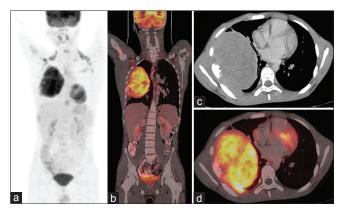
(a) Maximum intensity projection image showing fluorodeoxyglucose uptake in the right chest and brown adipose tissue (arrows) (b) coronal positron-emission tomography/computed tomography showing intense FDG uptake in a circumscribed heterogeneously enhancing soft-tissue mass with photopenic areas suggestive of necrosis, with compression/passive collapse of lung parenchyma. Mild FDG uptake is seen in the metaphyseal region of right humerus (arrow), with mild sclerotic changes (c) axial contrast enhanced computed tomography (d) axial PET/CT showing irregular sclerosis of the cortical margin of the right 6<sup>th</sup> rib
